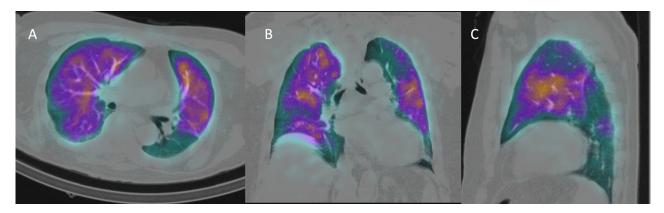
Hybrid Tc99m MAA SPECT-CT imaging in a patient with multiple segmental and subsegmental perfusion defects in keeping with pulmonary emboli. A. Axial, B. Coronal, and C. Sagittal views. The overlapping low-dose, non-enhanced CT slices provide an anatomic map and help better localization of each pulmonary emboli.
